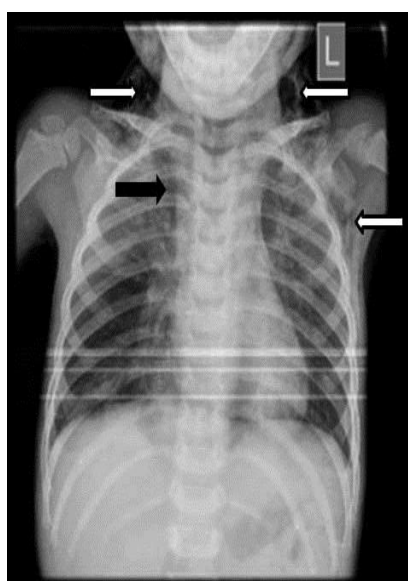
Neck and chest radiograph shows subcutaneous emphysema (white arrow) and pneumomediastinum (black arrow).
